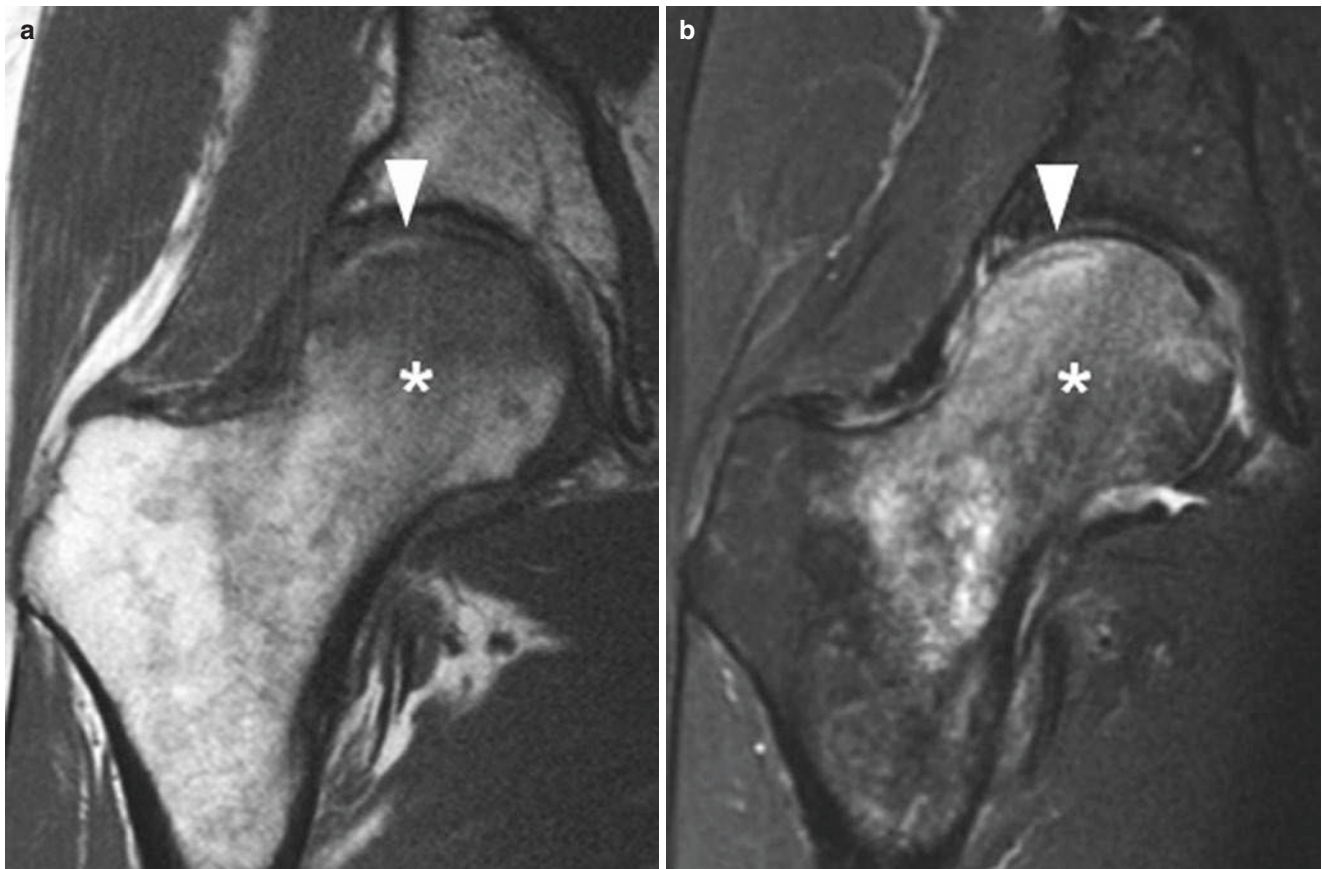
(a, b) Subchondral insufficiency fracture (SIF) of the femoral head. Coronal (a) T1-weighted TSE image, (b) intermediate weighted TSE image with fat suppression and (c) contrast-enhanced T1-weighted TSE image with fat suppression show a hypointense subchondral
